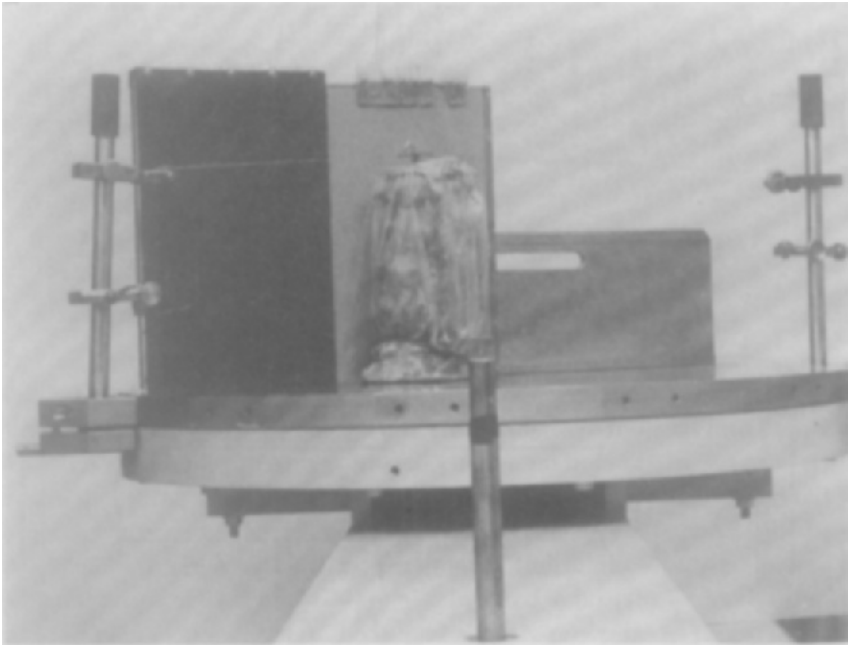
Roentgen apparatus. For description see text.
